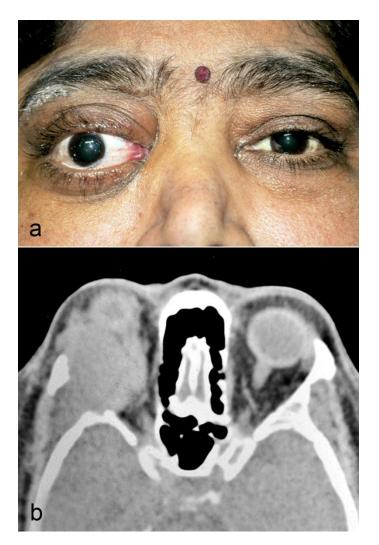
External photograph of the patient showing right eye proptosis with periocular swelling and mild conjunctival congestion (Fig 1a). CT Scan axial cut of the same patient showing a large mass occupying the lateral quadrant of the orbit with erosion of the lateral wall and extension into the temporal fossa (Fig 1b).
